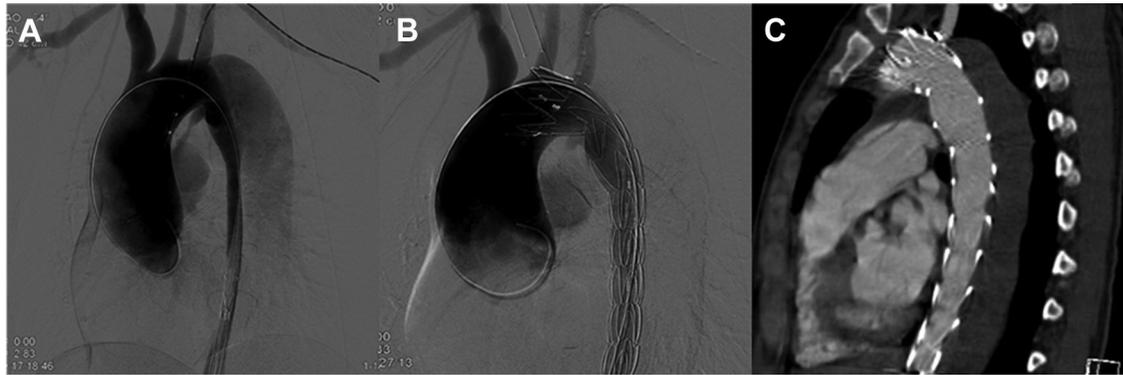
Thoracic Computed Tomography Angiography
